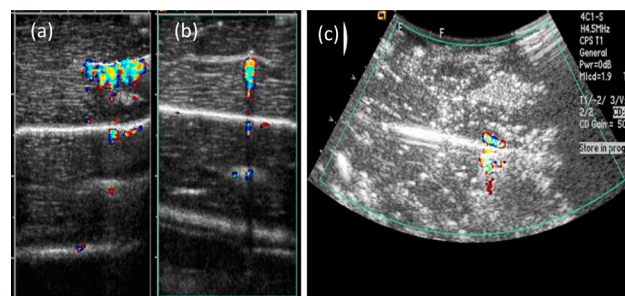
Color Doppler images of macrophase-separated PMCA/microshells film coated 18 mm needle in pork liver. (a) In-plane view of needle imaged with 15L8 transducer and an US frequency of 7 MHz. (b) Cross-sectional view of the needle imaged with 15L8 transducer and an US frequency of 7 MHz. The image sizes are larger than the needle due to the strong ultrasound signal. (c) In-plane view of needle using a 4C1 transducer and an US frequency of 3 MHz.
